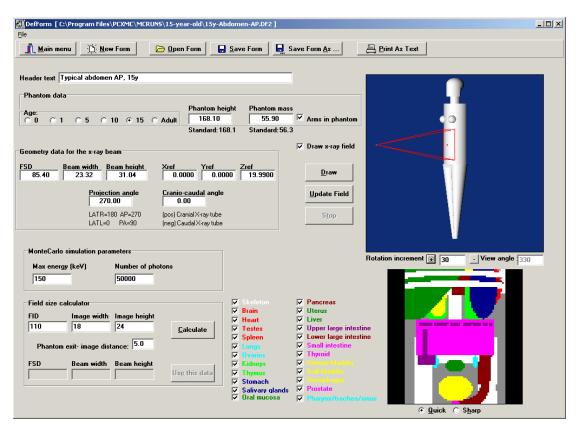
an example of the x-ray examination data input required for PCXMC (STUK, Helsinki)
